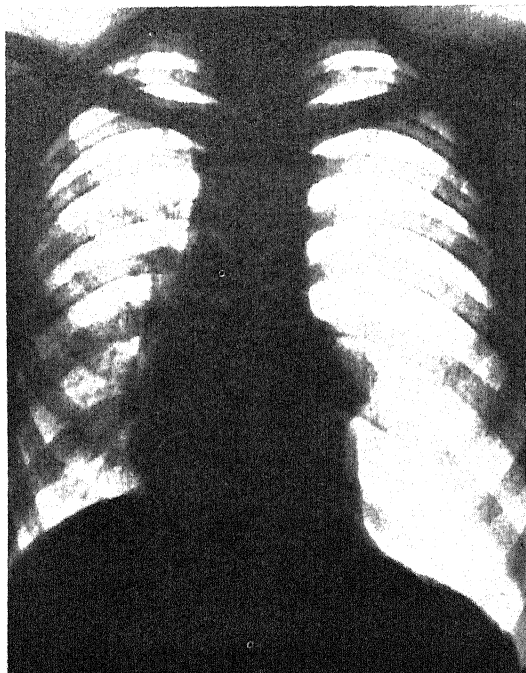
X-ray of a case of pneumothorax. Air has penetrated into the left pleural cavity, the lung on that side has collapsed and is reduced to a small mass around the hilum. The heart is displaced toward the right. The diaphragm is lower on the left side than on the right because there is no "negative" pressure, owing to the absence of the elastic recoil of the lung.
